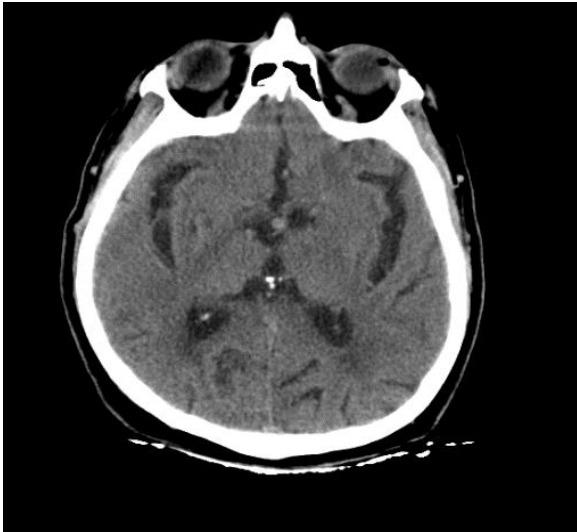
Computed tomography, axial section: The bleeding area is completely resorbed in the control computed tomography performed after discharge.
